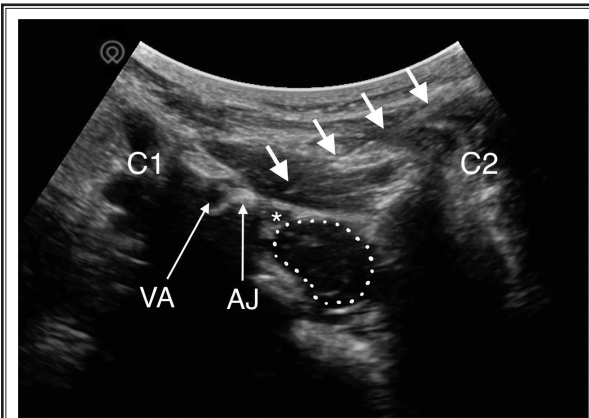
Ultrasound image showing the puncture needle reaching the target nerve (C2).*
